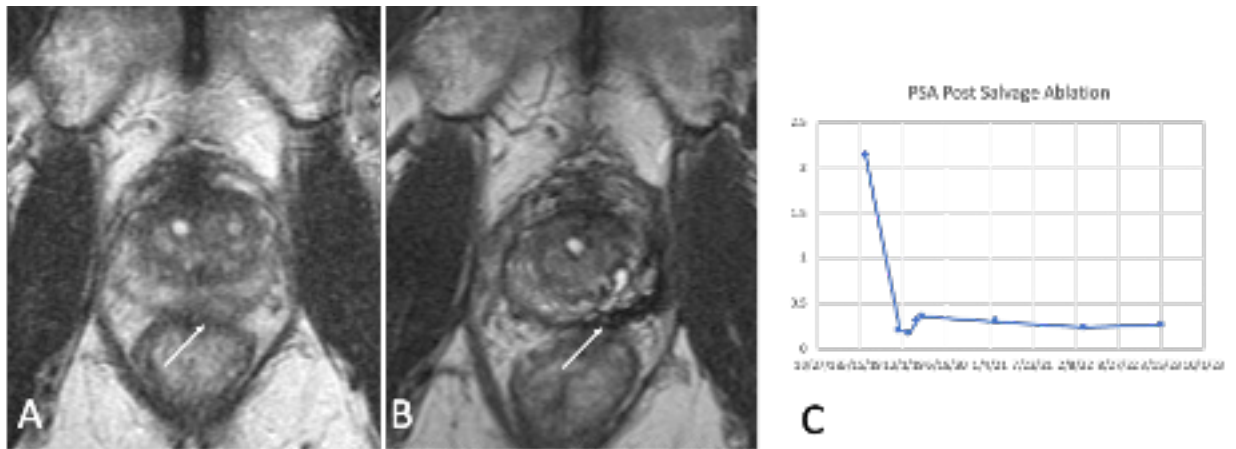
Post-ablation imaging and PSA: (A) pretreatment MRI, (B) 4-year post-ablation MRI demonstrating no evidence of tumor, (C) PSA course post ablation.
